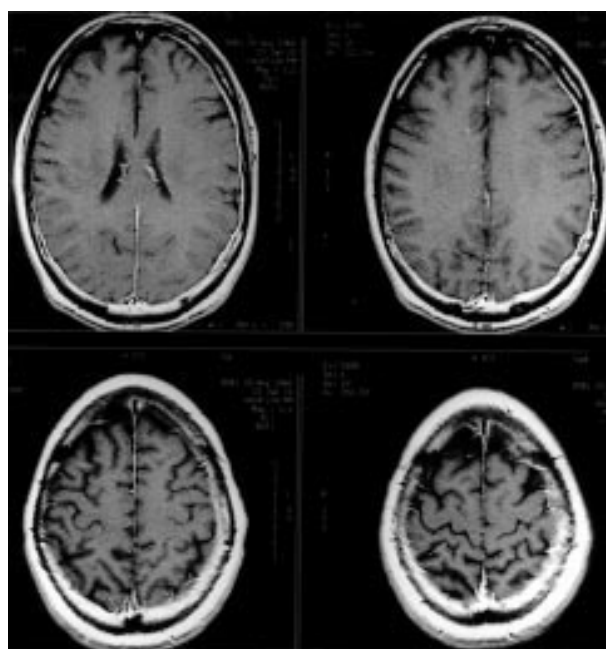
MRI showing diffuse meningeal enhancement.
